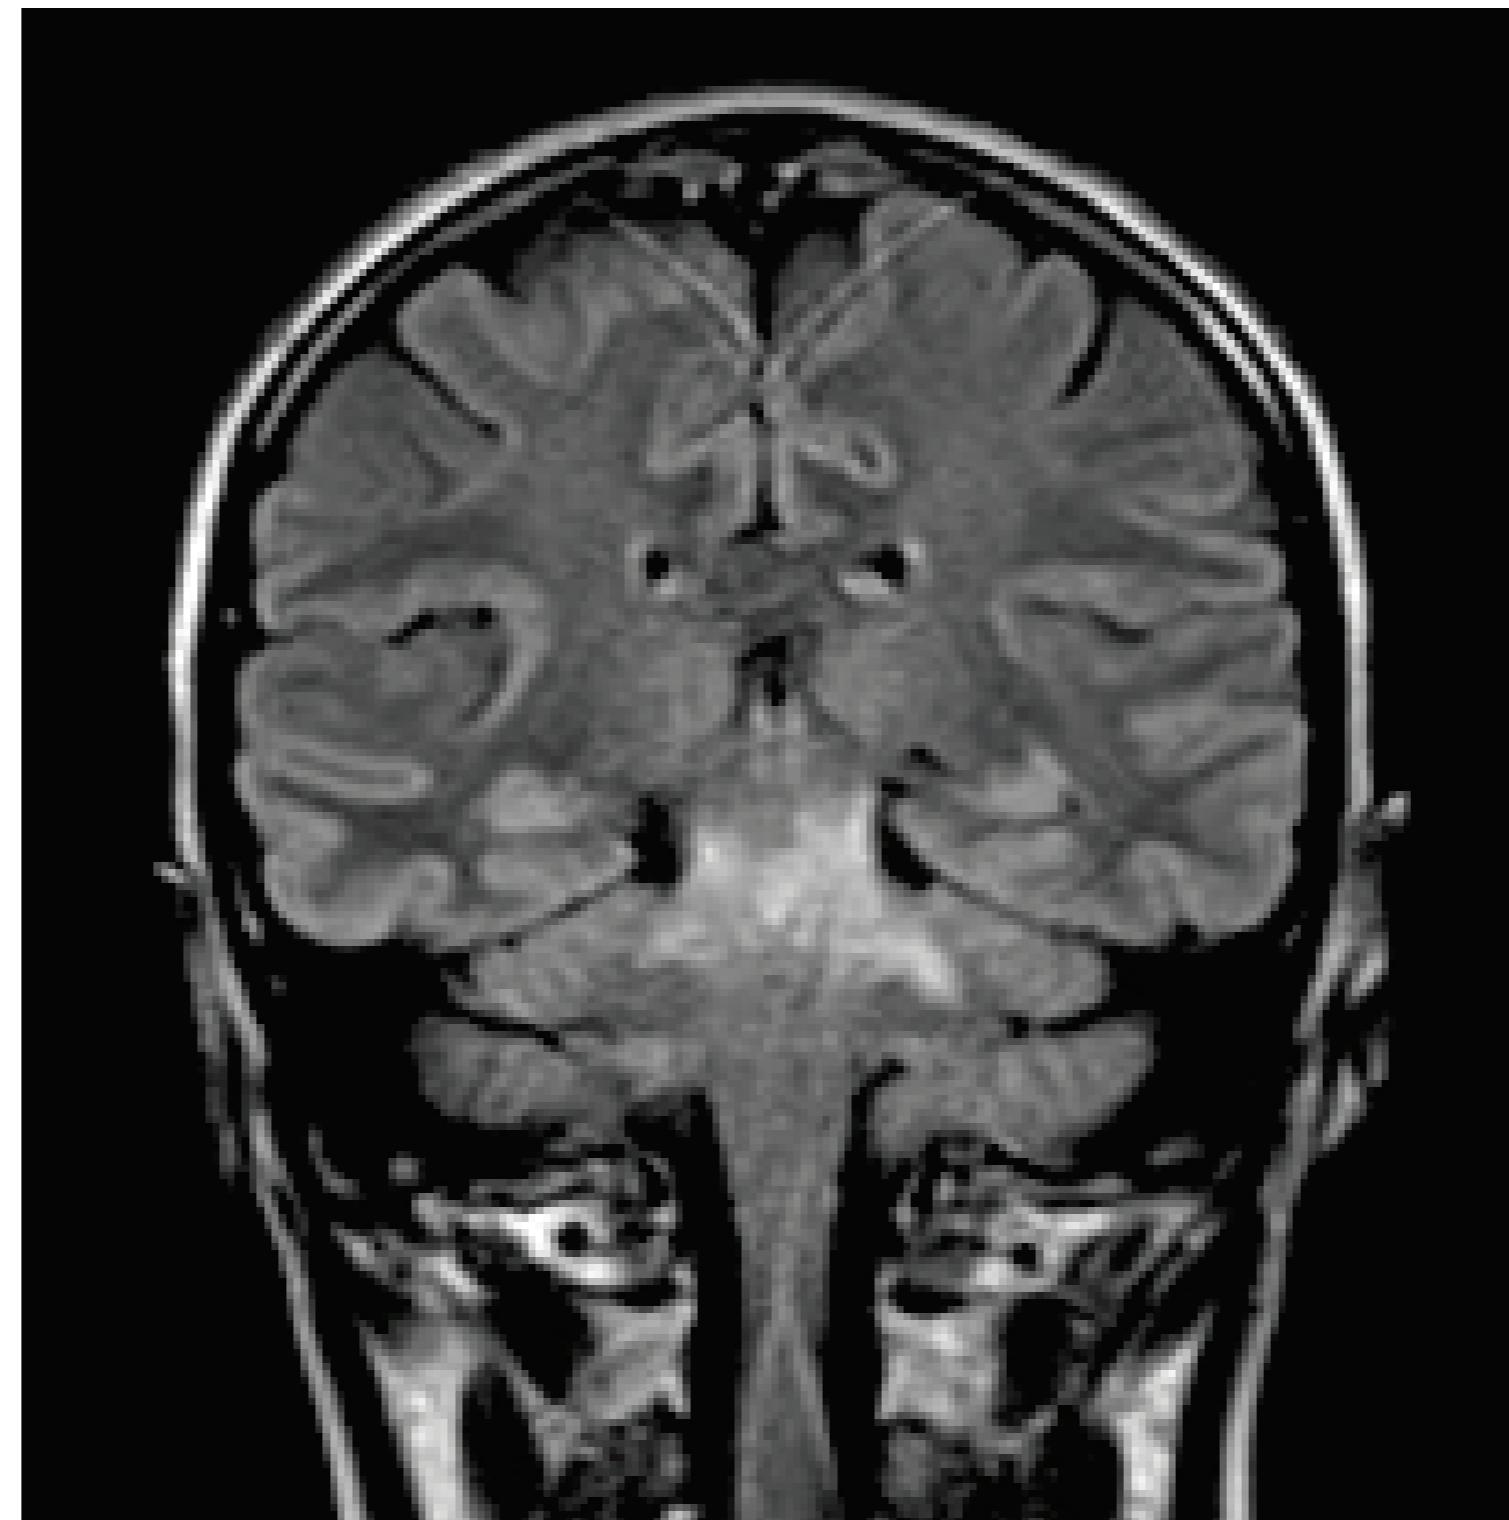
Admission MRI scan (FLAIR sequence, 05/2015) showing a massive pontine hyperintensity.
